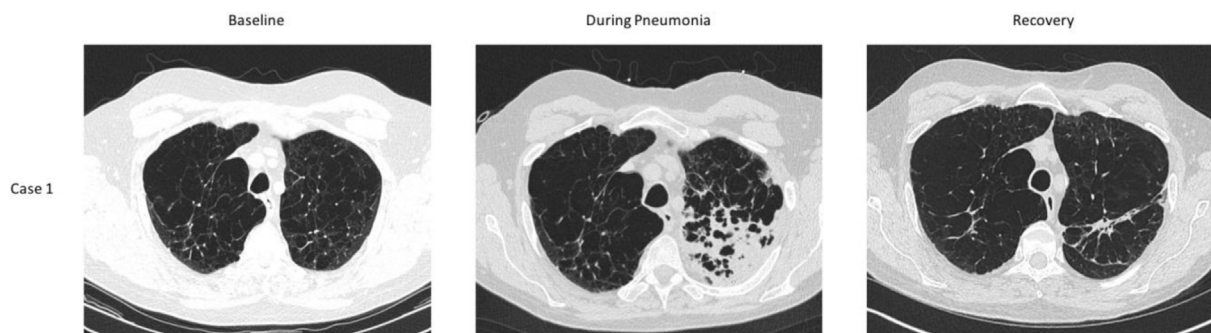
Case 1 CT chest: pre- during- and post-pneumonia. There is consolidation superimposed on emphysematous changes in the left upper lobe during the acute pneumonia. The CT post recovery demonstrates scarring in the left upper lobe, with volume loss, as evidenced by anterior displacement of the left oblique fissure compared to the baseline CT.
